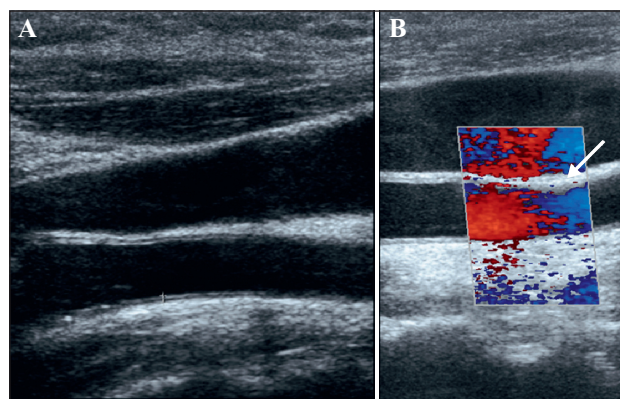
Doppler ultrasound examination.
